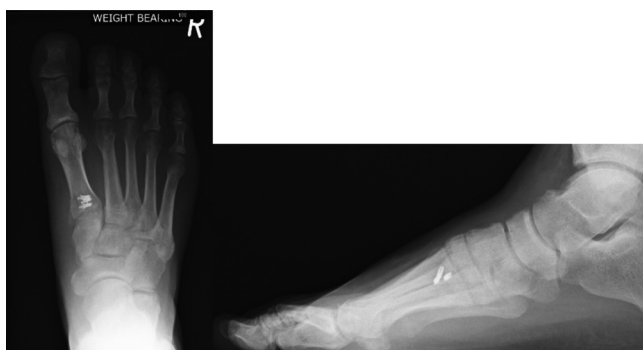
Radiograph at 8 weeks showing the healed avulsion fracture.
